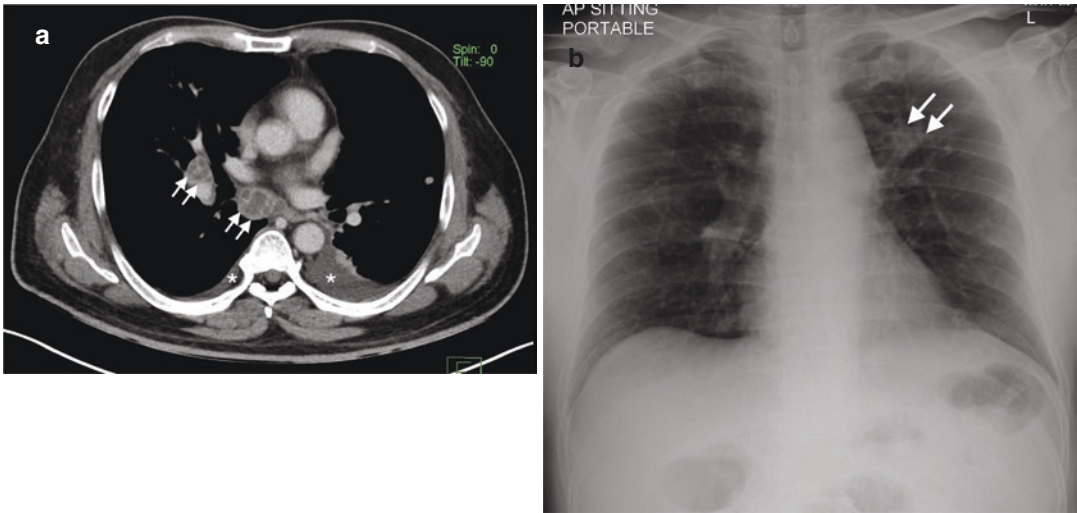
Pulmonary tuberculosis. (a) Axial CT image taken in the soft tissue window setting shows necrotic right hilar and mediastinal lymph nodes with a hypoattenuating center and rim enhancement (arrows), due to active tuberculosis. Small pleural effusions are also present bilaterally
